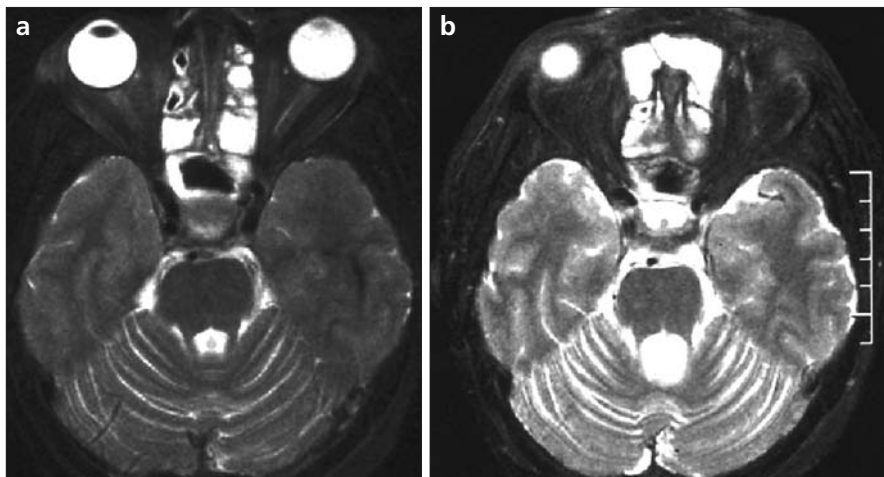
a, b. Transverse T2-weighted MR images taken one month apart (a and b, respectively) show the prominent cerebellar atrophy characterized by white matter loss and enlargement of the 4th ventricle. The final diagnosis was paraneoplastic cerebellar degeneration due to breast carcinoma.
